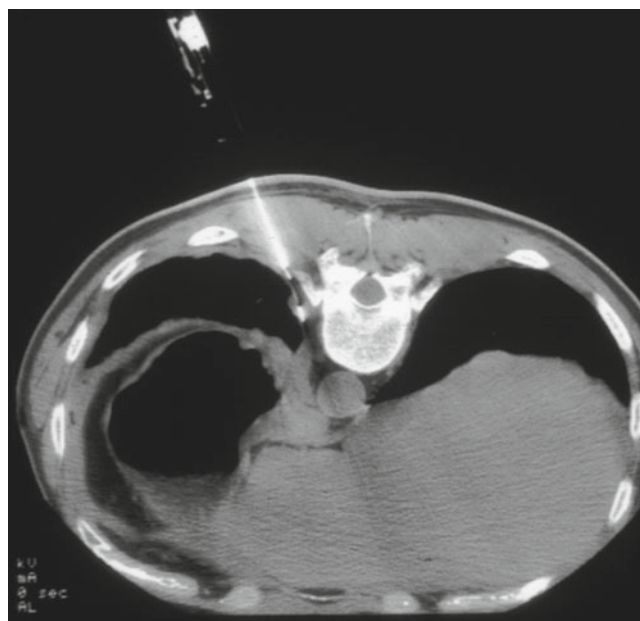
A CT-guided cutting needle biopsy of nodular irregular malignant pleural thickening
